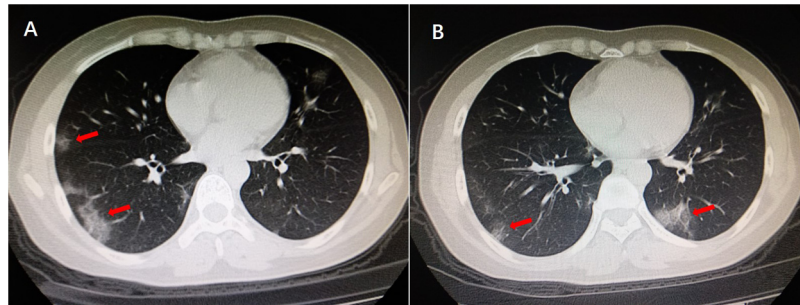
Chest HRCT images on 23 January 2020, showing multiple patchy ground glass opacities in bilateral subpleural areas (red arrows). HRCT, high-resolution computed tomography.
